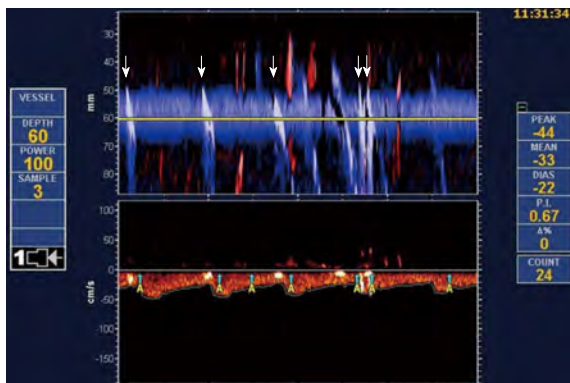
Transcranial Doppler bubble test showing the Doppler flow through the middle cerebral artery. The embolus is clearly represented in the power M-mode (upper panel) as a whitish sloping track. The whitish sloping track means that microemboli disrupt the ultrasonic signal (arrows).
